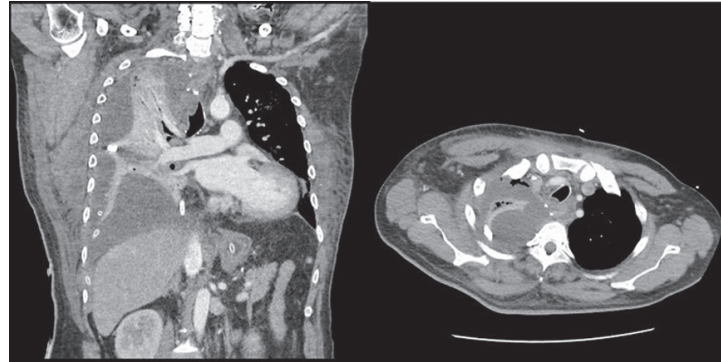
Contrast-enhanced computed tomography revealed free air at the cervical anastomosis site and massive lobulation effusion, compatible with gastric conduit necrosis and empyema thoracis.
